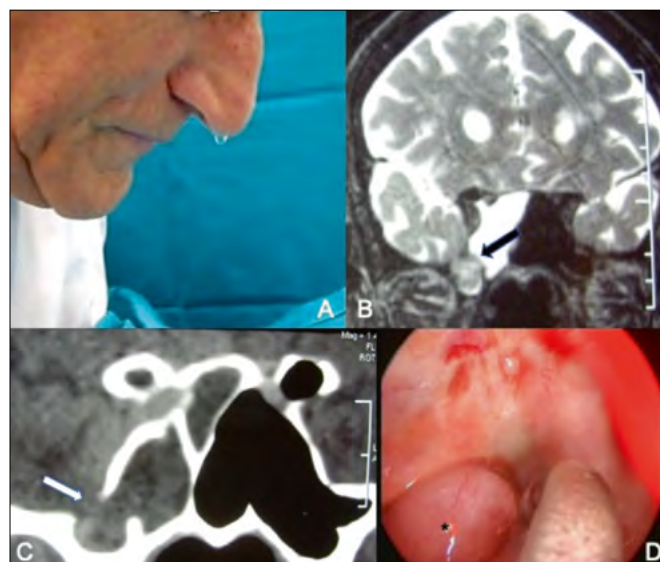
A case of spontaneous right nostril rhinoliquorrhea (A) in a patient with a meningoencephalocele in the right sphenoid sinus as showed in T2 weighted MRI (B arrow) through a bony defect (C arrow) in the lateral recess of sphenoid (Sternberg's canal) (C arrow) and how it appears (*) with 45° angled endoscopic examination of the sphenoid sinus.
